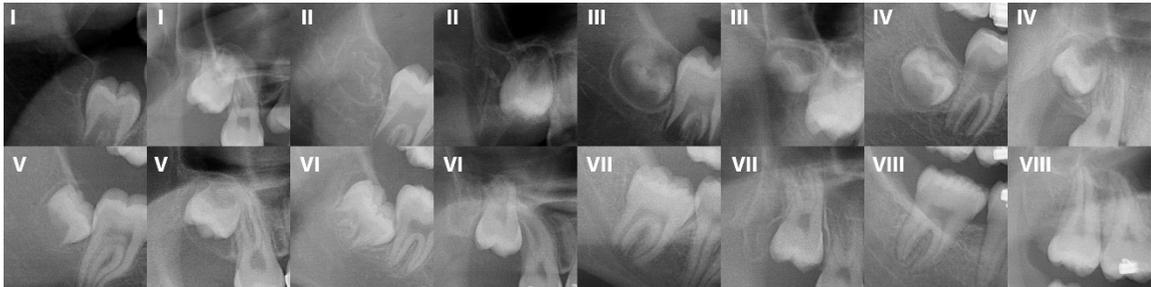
Radiographic representations of the eight stages of the classification of third molar developmental stages introduced in this study. Both maxillary and mandibular images are given for each stage. All images were taken from two dimensional digital panoramic images.
